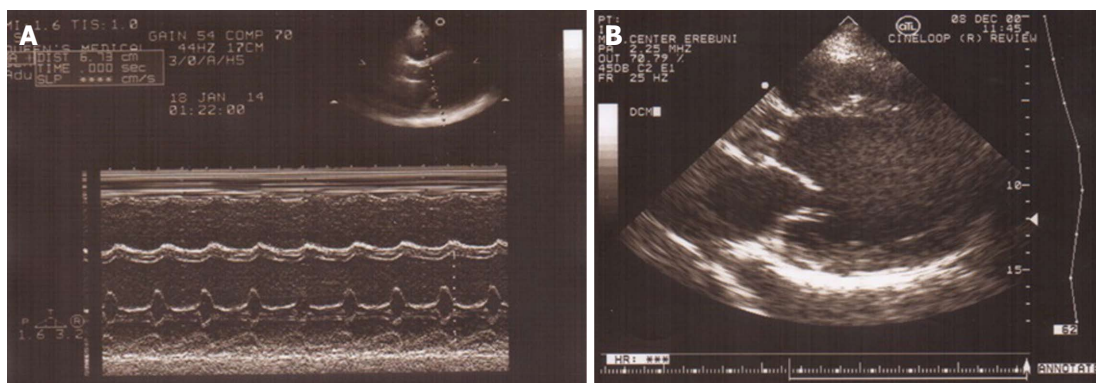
M mode and B mode echocardiogram of patient with idiopathic dilated cardiomyopathy. A: M mode echocardiogram shows dilated left ventricle with hypokinesis of interventricular septum and posterior wall; B: Parasternal long axis view of B mode echocardiogram showing remodeled left ventricular shape with loss of elliptical form.
